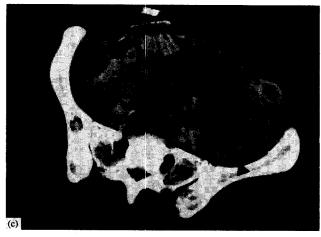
Computed tomography scans of the patient shown in Figure 4. Arrows indicate (a) large retroperitoneal tumour masses before chemotherapy (date 03/02); (b) a decrease of metastases during chemotherapy (date 04/09) and (c) progression of metastases before patient's death (date 06/03).
